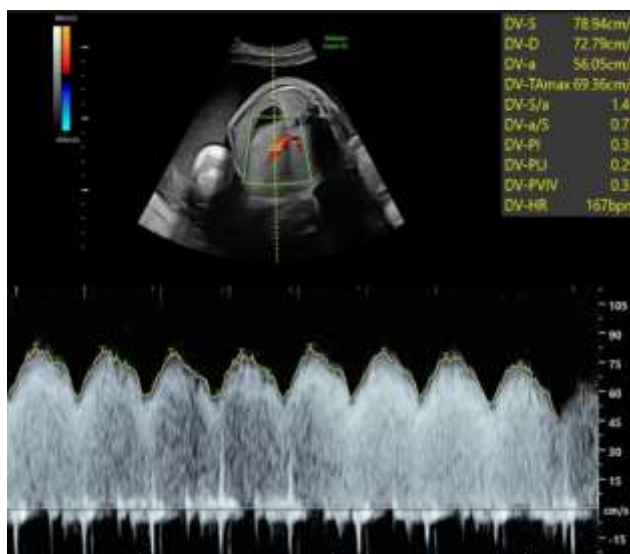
Ductus venosus Doppler for twin 2.
